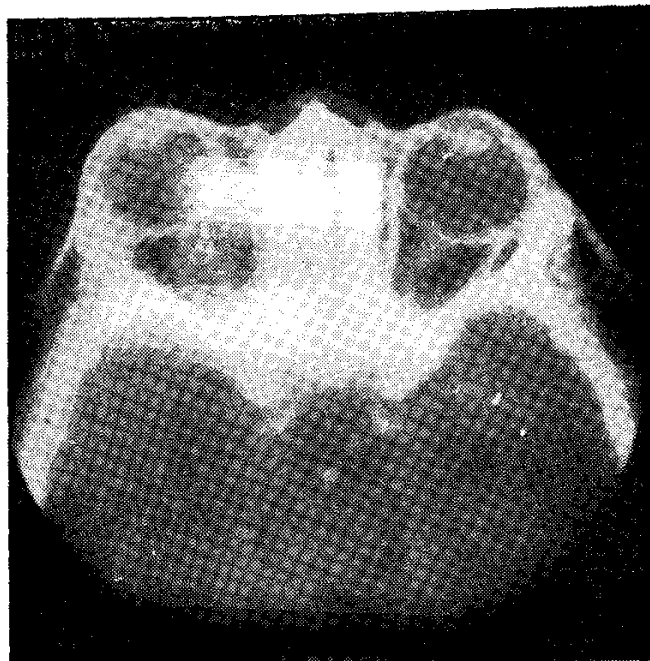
CT scan showing retrobulbar mass.
